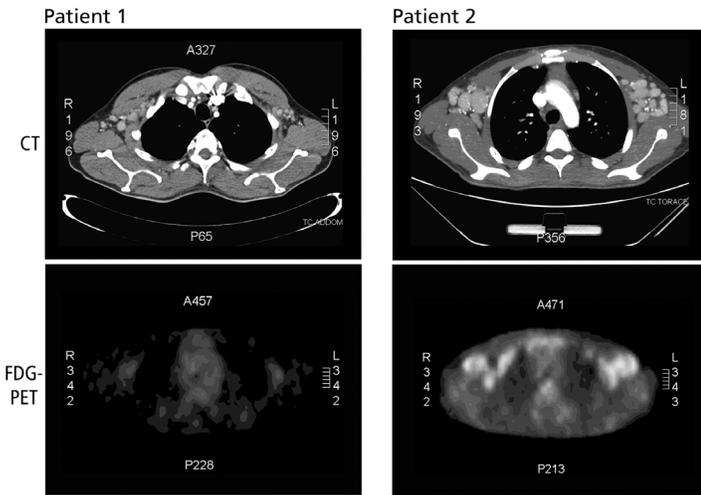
Computed tomography (CT) scans (upper panels) and [¹⁸F] fluorodeoxyglucose positron emission tomography (FDG-PET) scans (lower panels) on patients 1 and 2. CT scans show enlarged axillary lymph nodes in both patients. FDG-PET scan on patient 1 (lower left panel) does not show increased metabolic activity. FDG-PET scan on patient 2 has substantial pathologic accumulation of FDG.
